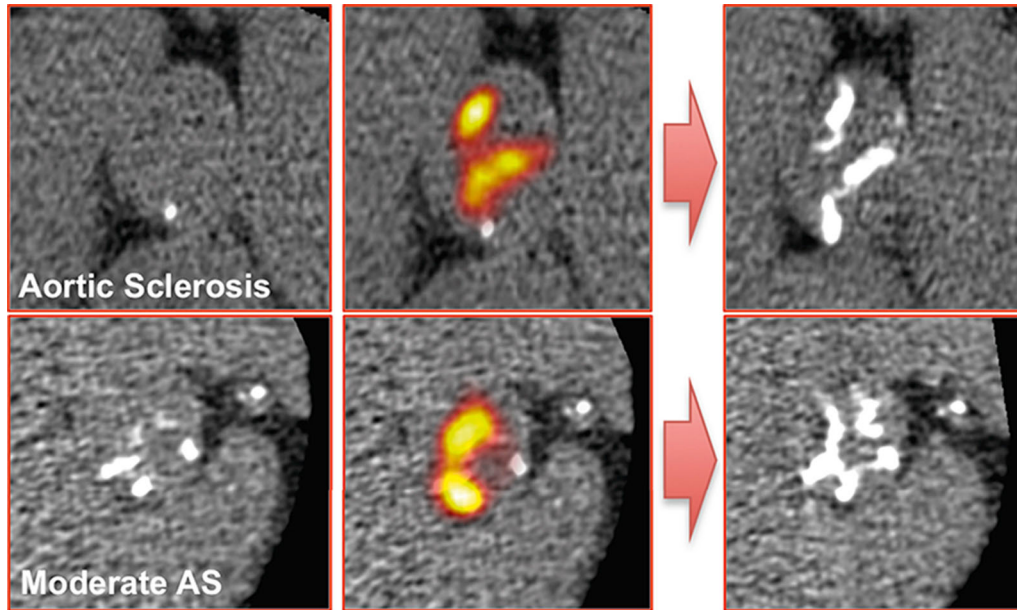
^{18}F -NaF imaging and progression of valvular calcification in CAVD. Baseline CT images (*left*) and fused ^{18}F -NaF-PET/CT images (*middle*), and 2-year follow-up CT images (*right*) in two patients with CAVD. Adapted with permission from Elsevier and Copyright Clearance Center, Journal of the American College of Cardiology,³⁸ © 2015.
